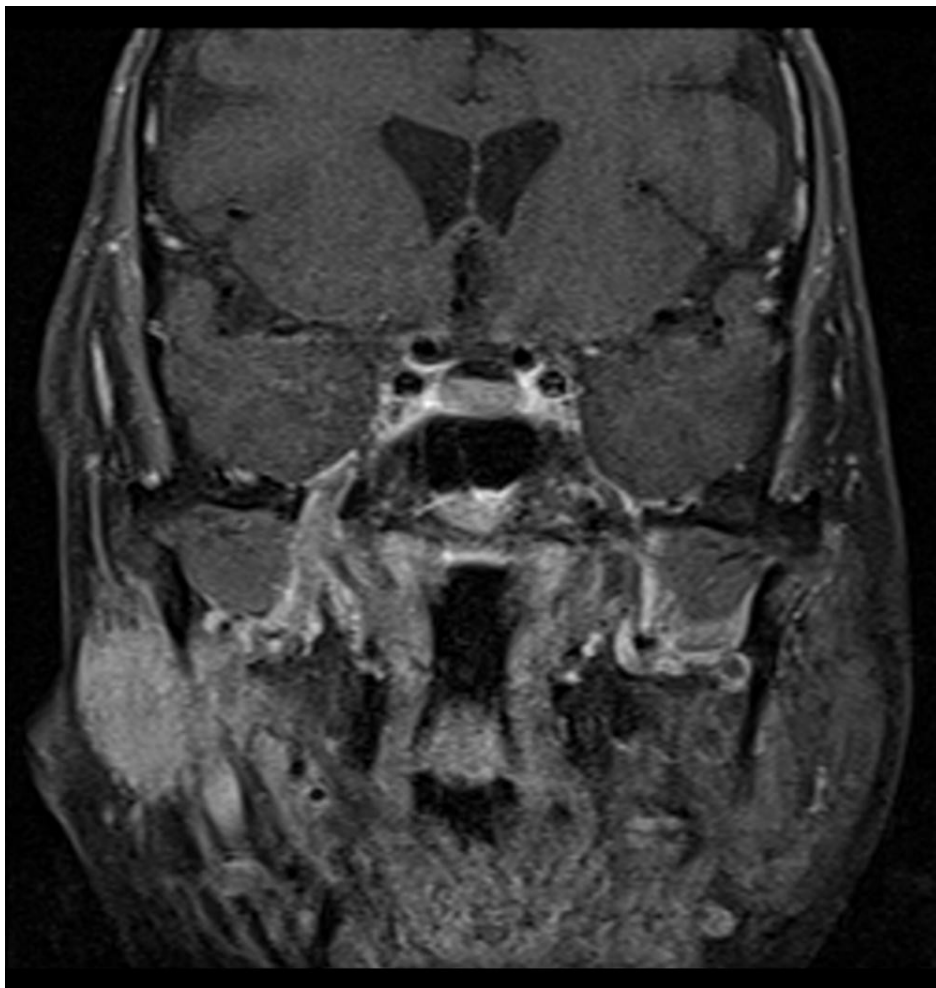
Coronal fat-suppressed postcontrast T1 MRI demonstrating parotid adenoid cystic carcinoma with perineural spread along a trigeminal pathway. Jto410, CC BY-SA 3.0, via Wikimedia Commons. Named-nerve spread changes both the resection map and the postoperative treatment field.
